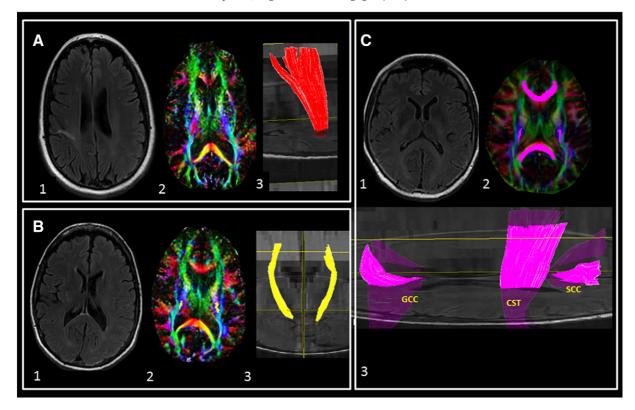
Below are provided pictorial examples of subjects studied in this study with depictions of the 3D Tract Reconstructions for each subject. A) 50 year old female, with mRS and NIHSS of 2 in the setting of a small right parietal infarct seen on FLAIR (1) and A 54 year old female, with an mRS of 1, NIHSS of 2 in the setting of a small right corona radiate/internal capsule infarct seen on FLAIR. B) 54 yr. old female, with an mRS of 1, NIHSS of 2 in the setting of a small right corona radiate/internal capsule infarct seen on FLAIR. Both A and B depict typical subjects in this study with small infarcts and no visible abnormalities in the corticospinal tracts on color maps or on 3D reconstructions. C) A control subject, a healthy 66 year old female, normal FLAIR (1), normal appearing color map, (2), depicting the 3D-reconstructions of three major fiber bundles chosen for analyses (3), GCC: Genu of Corpus Callosum, SCC: Splenium of corpus callosum and CST: Bilateral corticospinal Tracts.
